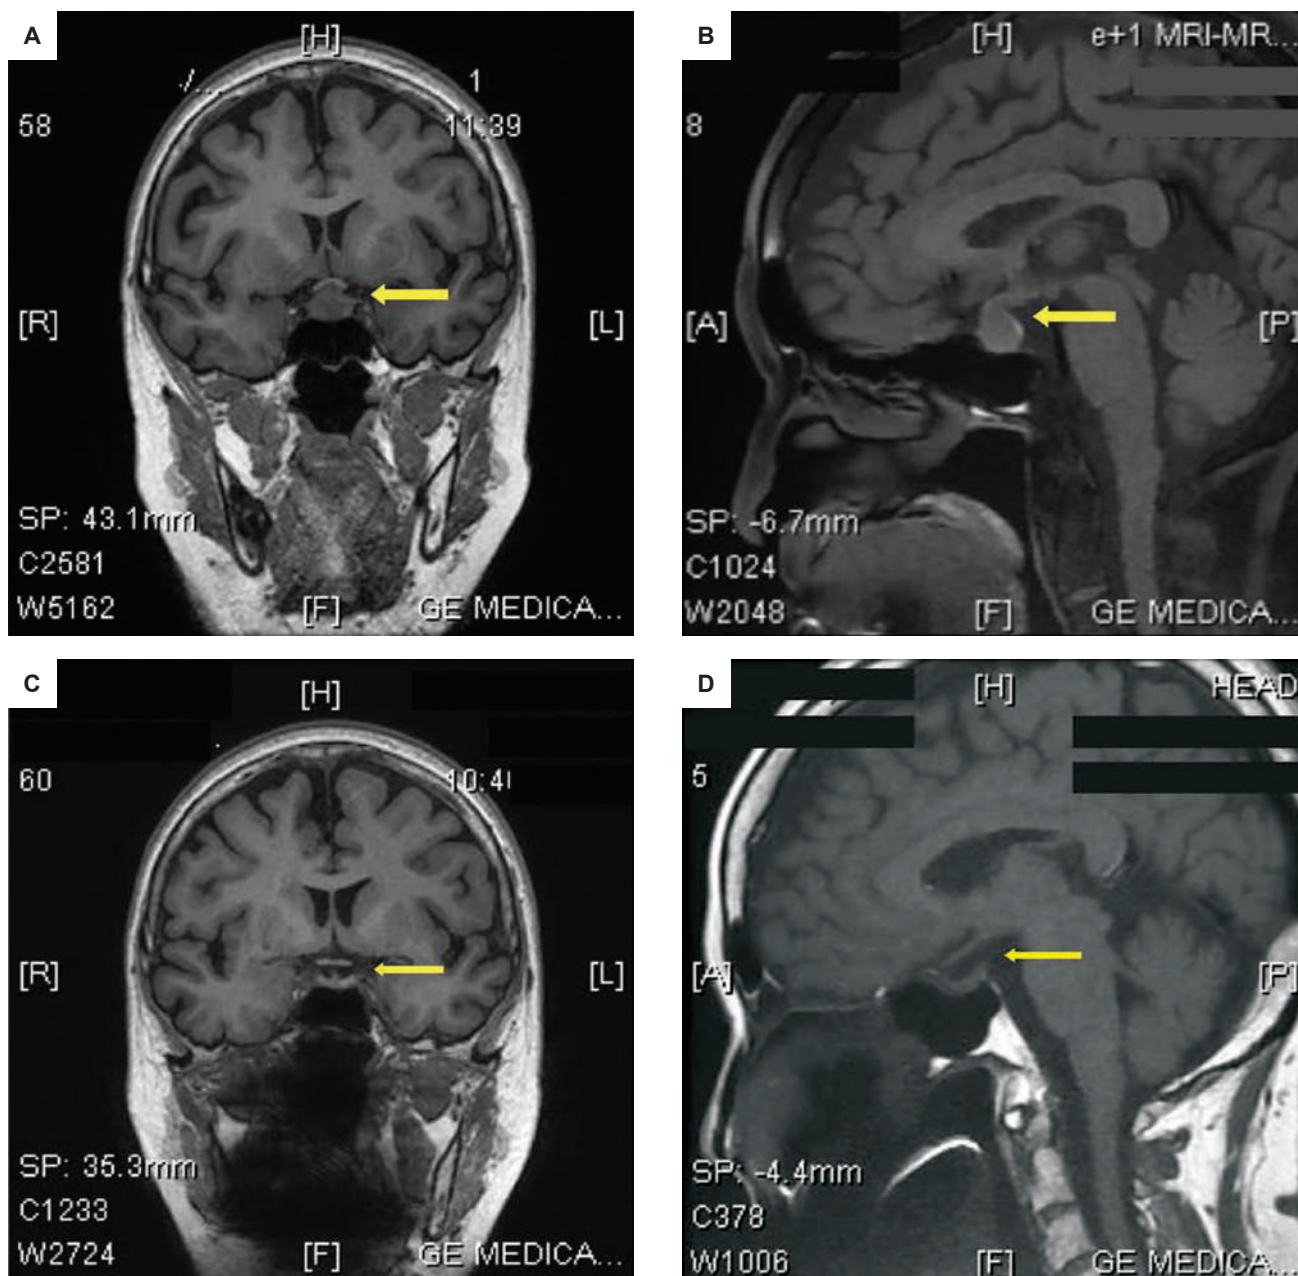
Preoperative cranial magnetic resonance imaging (MRI) in (A) coronal and (B) sagittal views showed an enlarged pituitary gland, with a 1.3 cm x 1.3 cm x 1.4 cm enhancing suprasellar nodule indenting the optic chiasm. Features of cystic degeneration, calcification and hemorrhage were absent. After transsphenoidal surgery, MRI showed interval resolution of the previously noted pituitary nodule, with normal appearance of the pituitary gland, optic chiasm and pituitary stalk on (C) coronal and (D) sagittal views.
